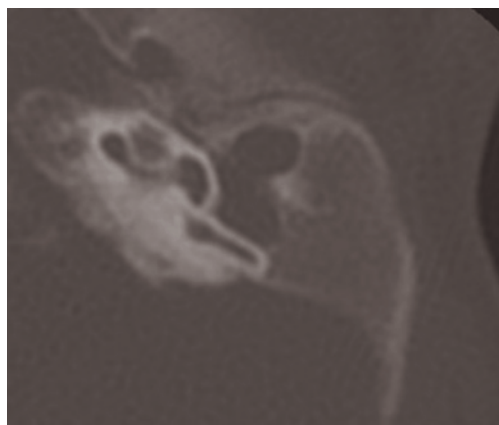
Axial CT scan. Two-month-old female with left atresia and absence of the ossicles. Mesenchyme occupies the middle ear.
